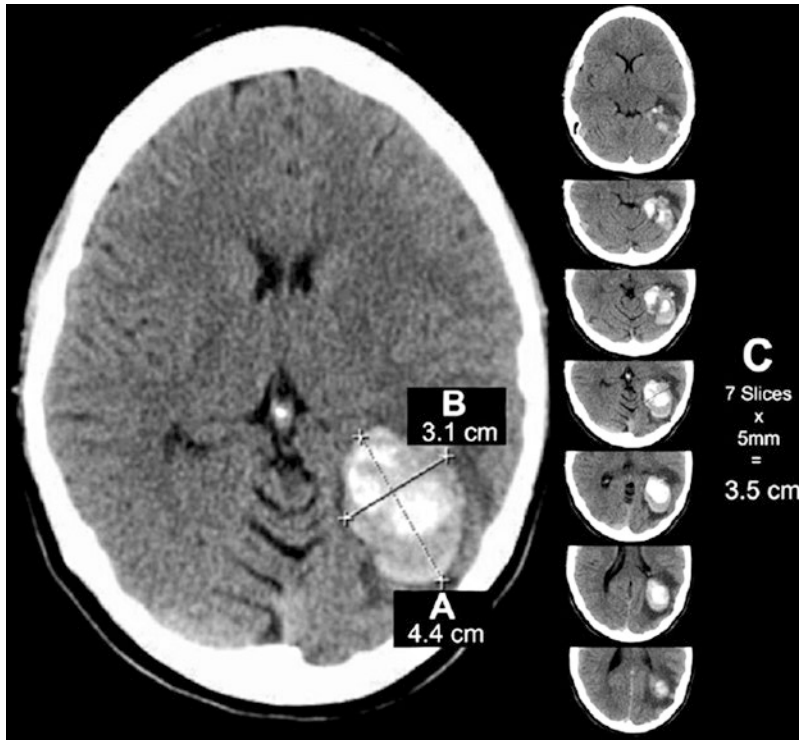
Example of ICH calculation using ABC/2 formula. (a) Greatest hemorrhage diameter by CT. (b) Diameter 90° to A. (c) The approximate number of CT
